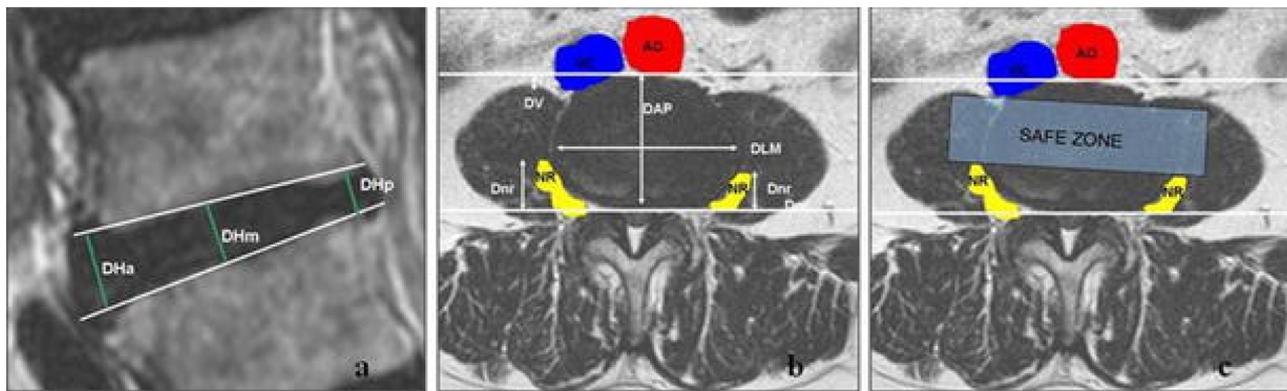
Axial MRI scan demonstrating the safe working zone for the lumbar lateral interbody fusion procedure between the exiting nerve roots dorsally and retroperitoneal vessels ventrally. Reprinted with permission from Guérin P et al.¹⁴ MRI, magnetic resonance imaging.
